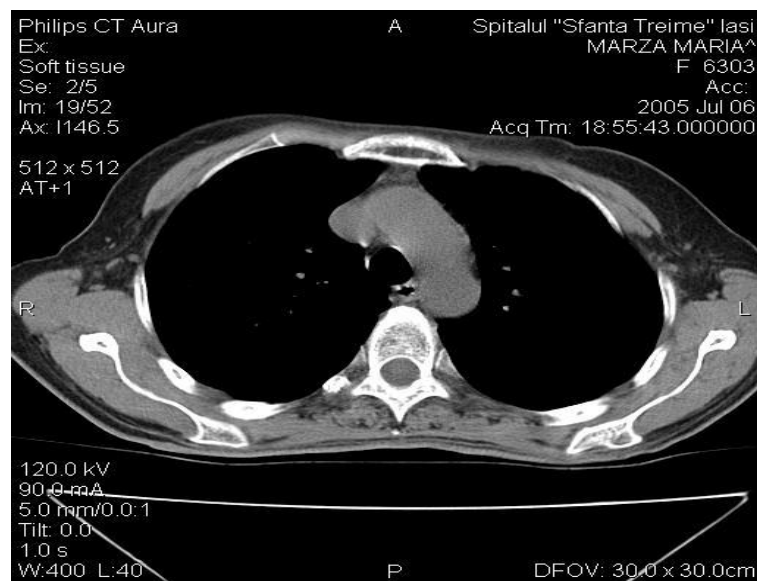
Thorax CT with heterogenous increased size thymic region.
